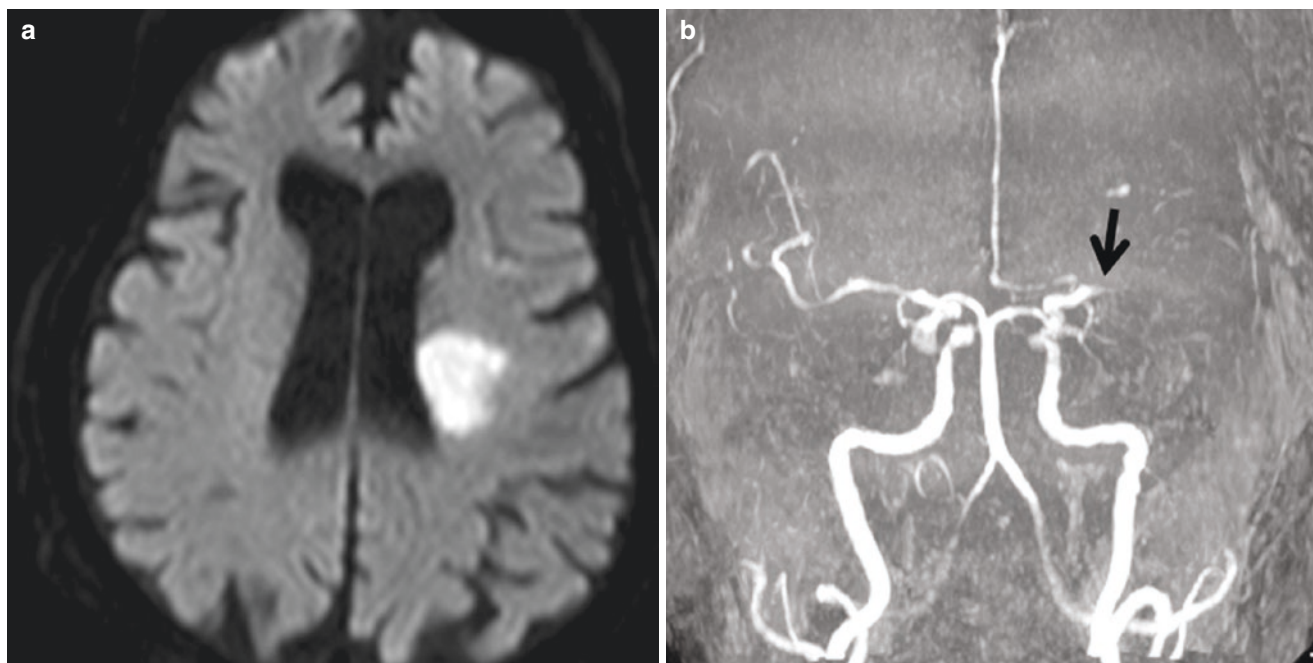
MRI in EVT selection. (a), DWI shows acute infarction of left basal ganglia with the estimated core volume of 20 ml by $A*B*C/2$ method. (b), 3D TOF MRA shows left MCA occlusion at the origin
